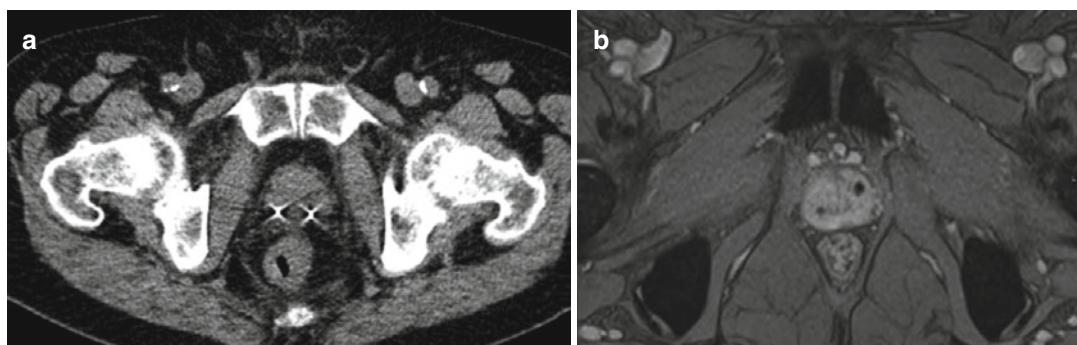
Fiducial (gold grains) marking the position of the prostate for radiotherapy planning. (a) Axial CT shows two gold grains with the prostate. (b) Gradient-echo (T2*-weighted) images show the fiducial markers as signal voids
